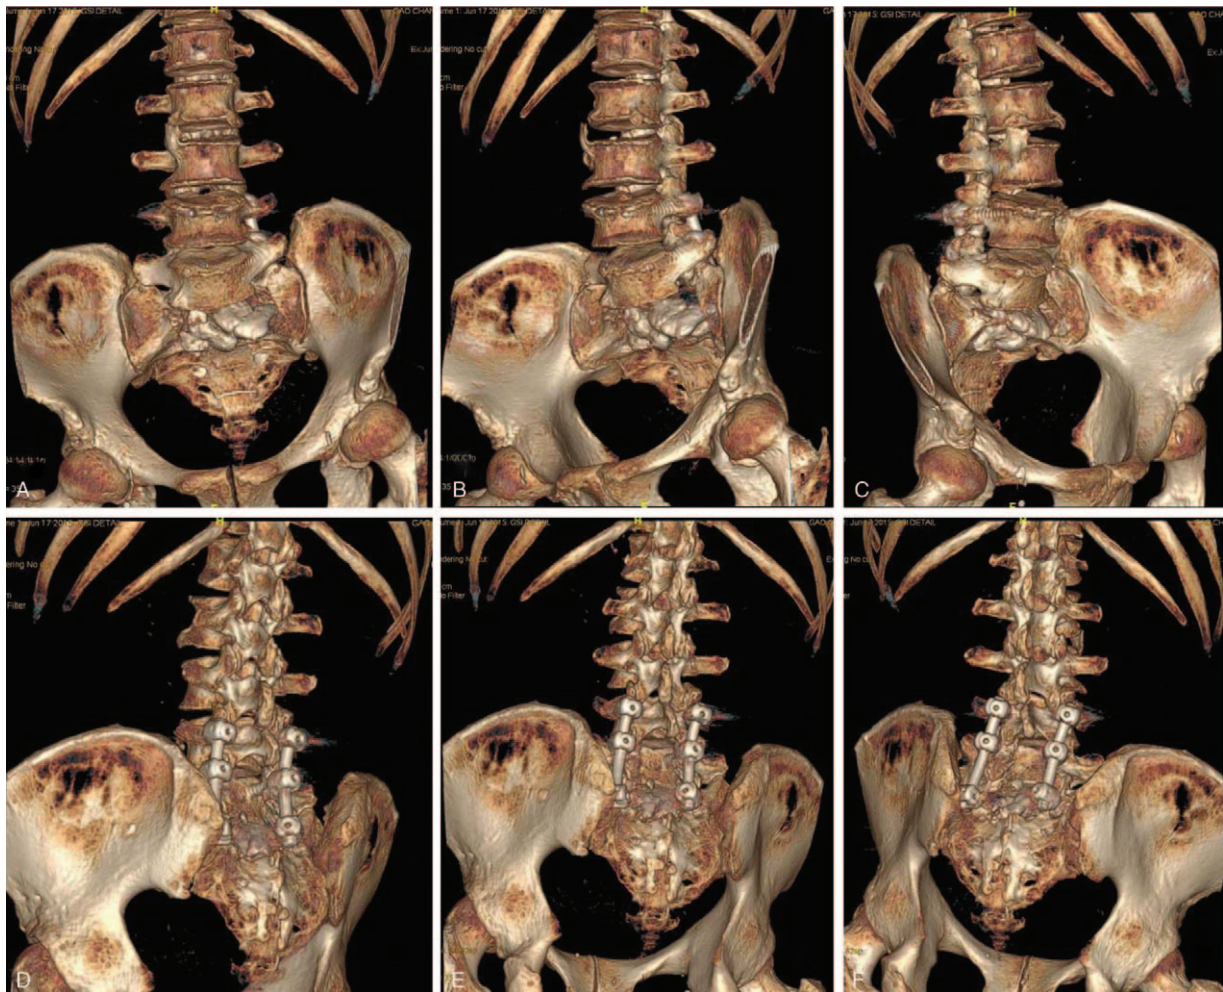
(A–F) An emergency lumbar de metal artifact CT examination showed that the position of the right pedicle screw at L5 was not good enough and might stimulate the nerve root. CT=computed tomography.
